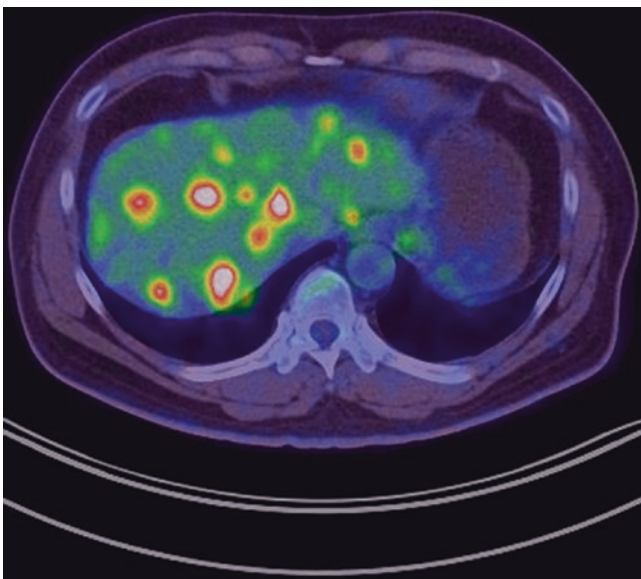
FDG PET-CT fused image shows diffuse liver metastases
